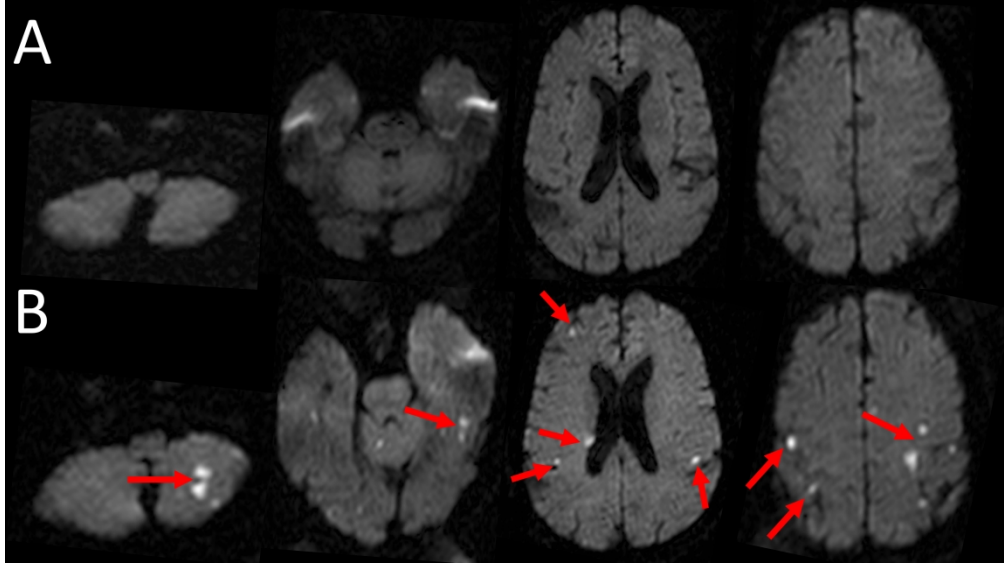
Diffusion weighted MRI of the brain examining silent injury with TAVI. Cerebral images, including the brainstem and cerebellum before (A) and after (B) TAVI procedure. Multiple new cerebral infarctions were seen, some of which are highlighted by the red arrows.
